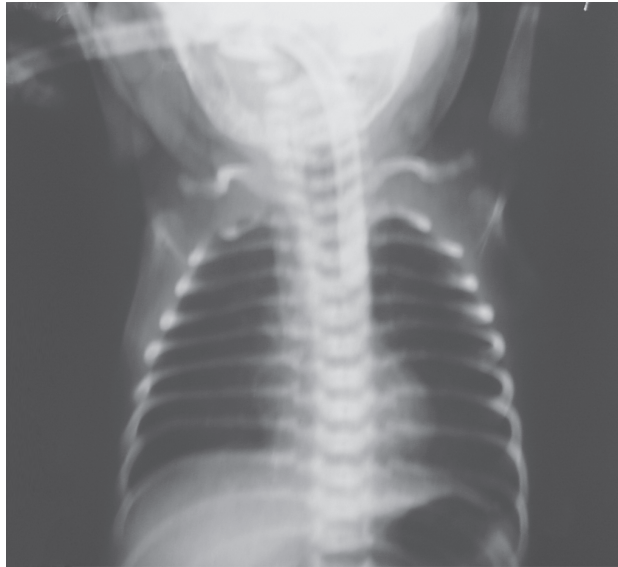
X-ray of the blind upper pouch with red rubber catheter *in situ*
